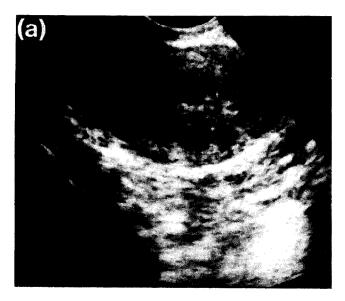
Tamoxifen and the endometrium. Images of transvaginal ultrasonography. (a) A 25 mm thickened endometrium with cystic appearance: endometrial polyp-cancer; (b) A 9 mm thickened endometrium: glandulocystic endometrial atrophy; (c) A rectilinear endometrium with a 5 mm thickening of the uterine fundus; (d) Saline infusion sonography: benign endometrial polyp (same patient as in (c)).
